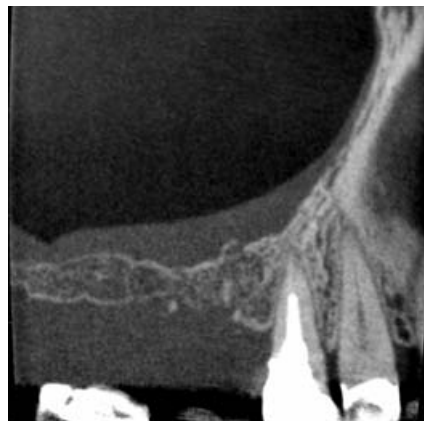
Sagittal CBCT image
